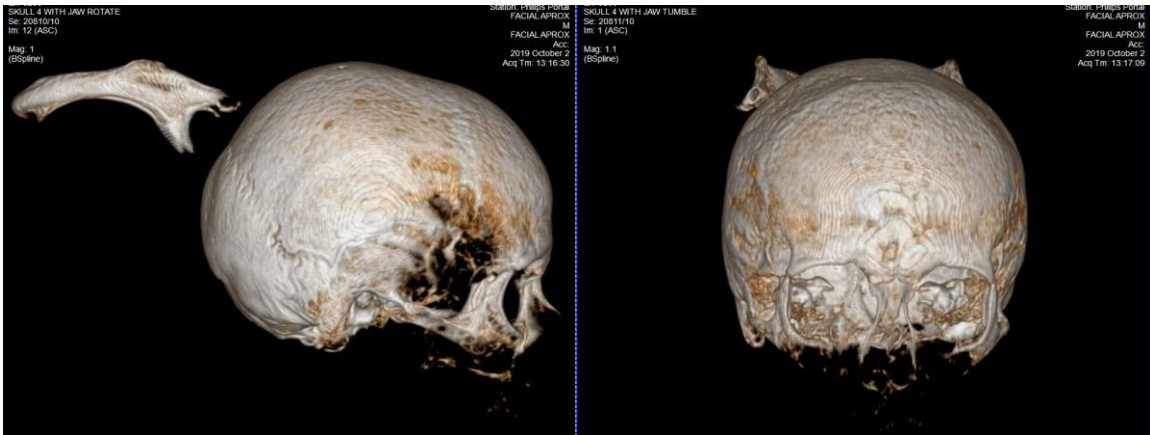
CT scan of skull 4. Left lateral and anterior views.
